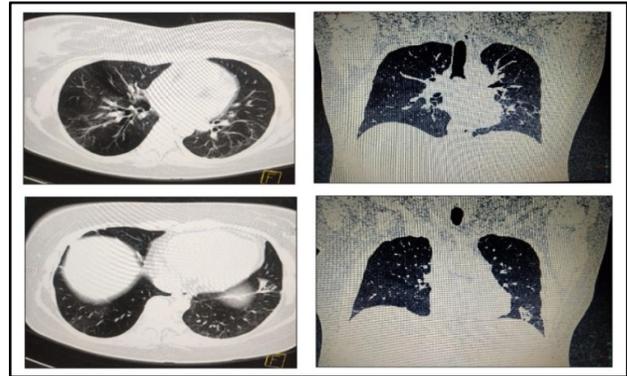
Multi planner high-resolution CT scan of the chest showing fine fibrotic changes with ‘air trapping’ in both lungs (postnatal period).
